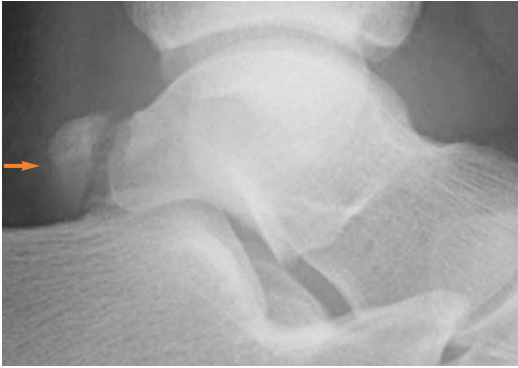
Lateral X-ray of the ankle: os trigonum (arrow)
